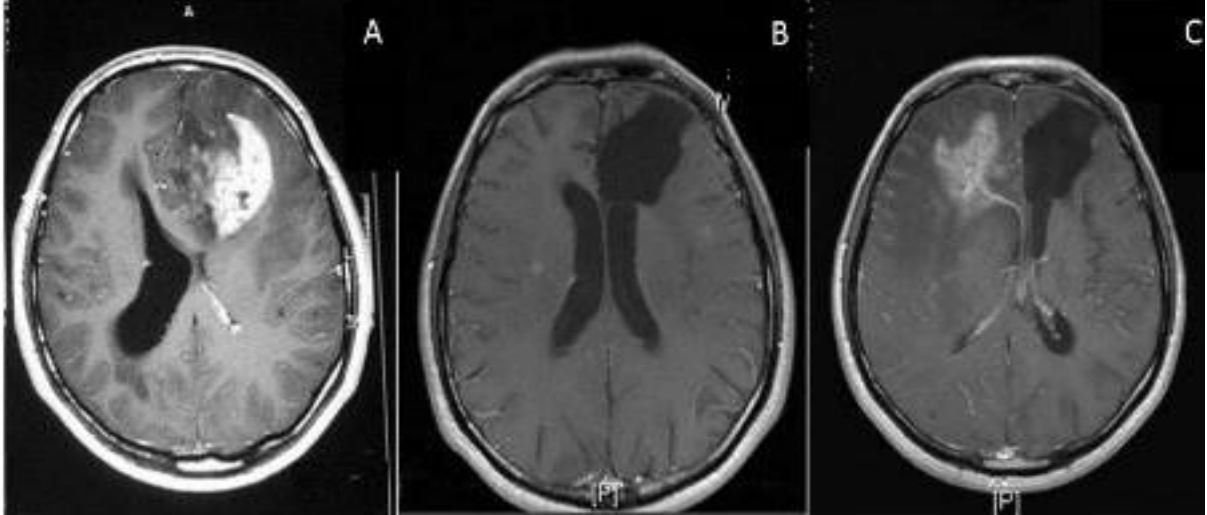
MRI result of GBM patient. (a) Before surgery. (b) After surgery. (c) Recurrence of tumor after 18 months of therapy (image by Prof. Dr. Ihsan Solaroglu)
